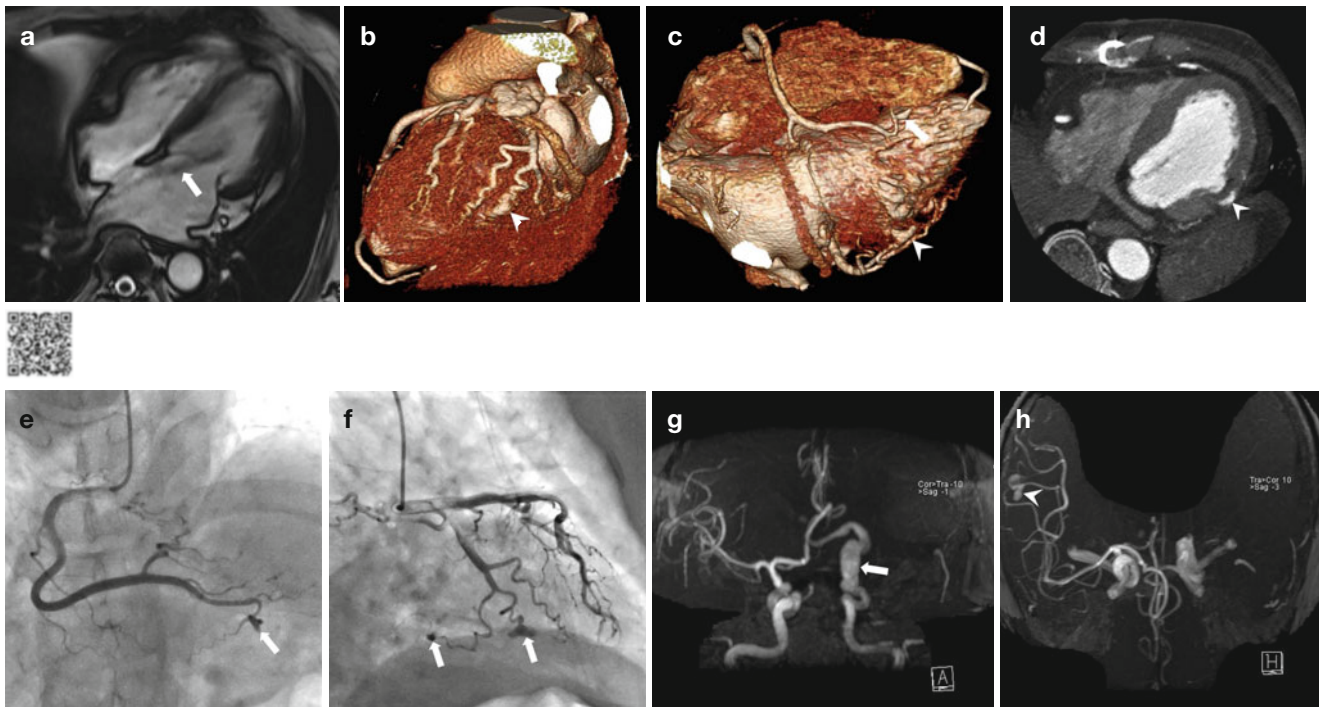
A 58-year-old woman with cardiac myxoma-related multiple cerebral and coronary aneurysms. This patient has suffered from repetitive episodes of stroke with right-sided hemiplegia and dysarthria for 20 years. (a) Four-chamber MR image shows an elongated mass (arrow) attached to the left atrial septum. The mass was confirmed as myxoma (<http://extras.springer.com/>). (b, c) 3D volume-rendering images show multiple peripheral fusiform aneurysms of the posterior descending artery (arrow) and the obtuse marginal artery (arrowheads). (d)
